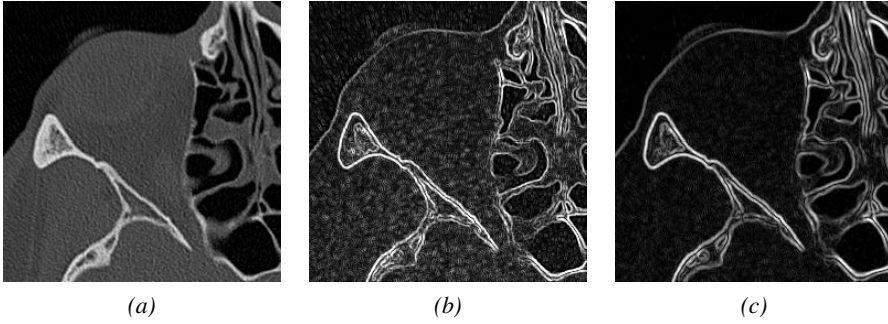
Edge detection: (a) original grayscale CT image $f(\mathbf{x})$; (b) gradient magnitude $\|\nabla f(\mathbf{x})\|$ computed with the central difference operator; (c) gradient magnitude computed with the Gaussian gradient operator.
